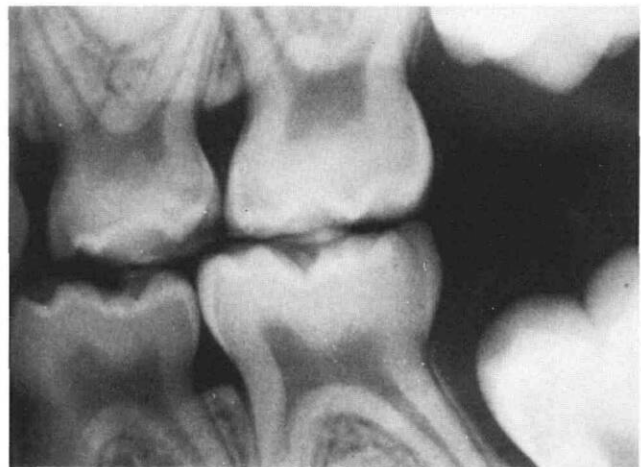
Radiograph of the occlusal borders of pulpal chambers of primary molars shows superimposing cuspal images. Clarification of these overlapping images would aid radiographic interpretation and planning of treatment.
